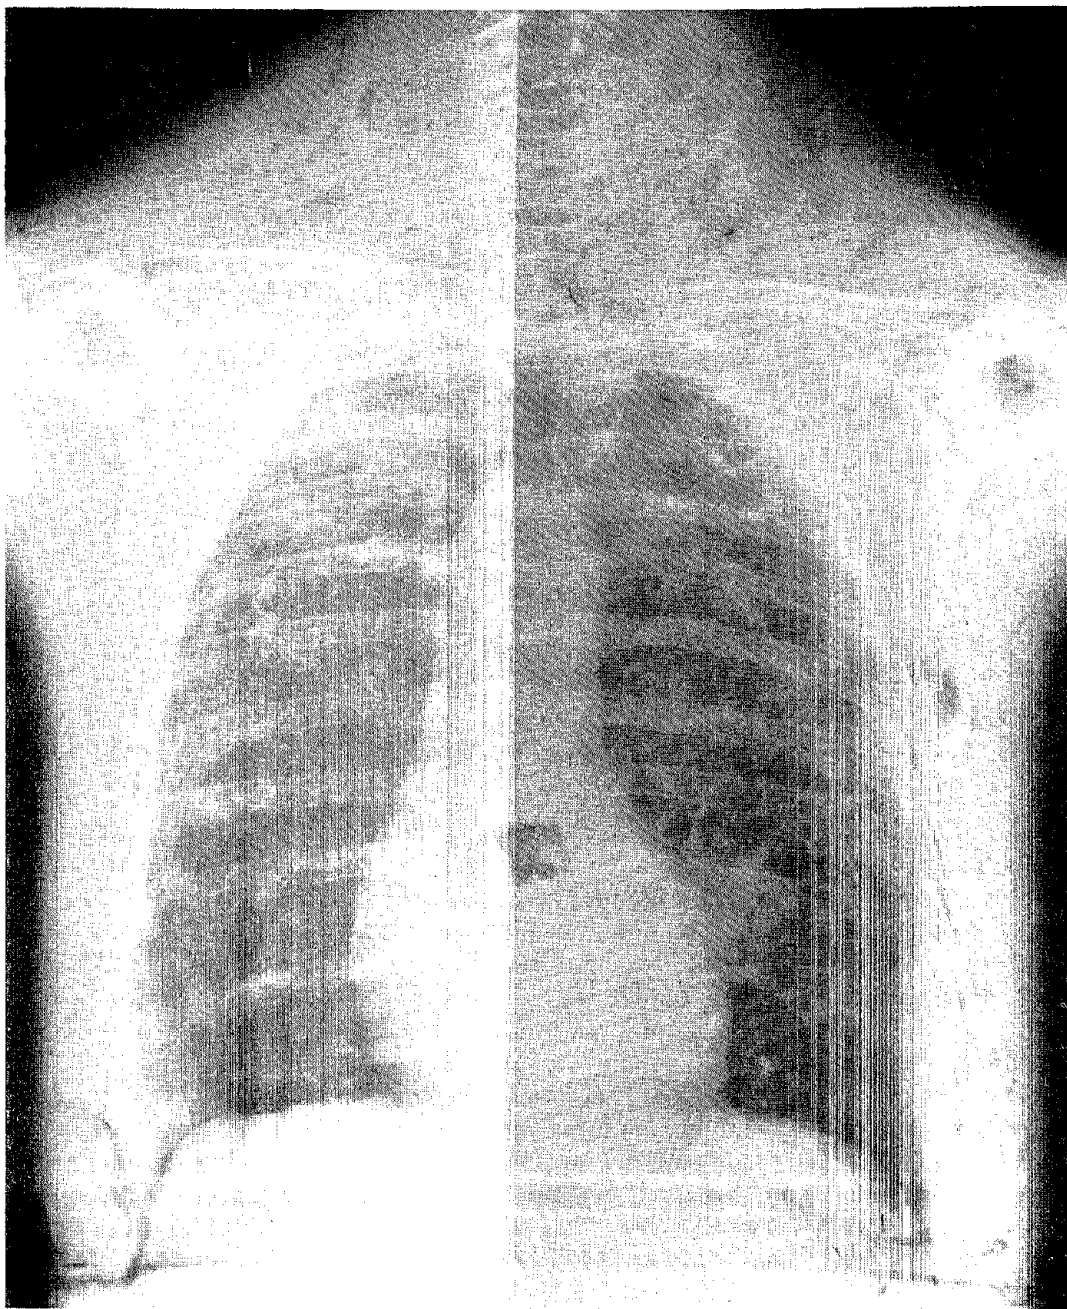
Results of film mishandling. The left side of this radiograph is darker than the other because another sheet of film was placed on top of the right half to protect it as it lay on the loading bench under the safelight before being processed. The glass filter in this safelight was intended for use with blue-sensitive films and this radiograph was made with an orthochromatic film (sensitive to green as well as blue light). Consequently after only a few seconds of exposure to this incorrect safelight, the fog density seen on the left was produced on the uncovered side of the radiograph along with a lowering of contrast in this part of the image. Notice, also, the thumbprint over the heart shadow caused by a wet hand, and the black crescent-shaped crimp marks over the left neck, apex of the left lung and lower left chest resulting from kinking of the film through careless handling.
